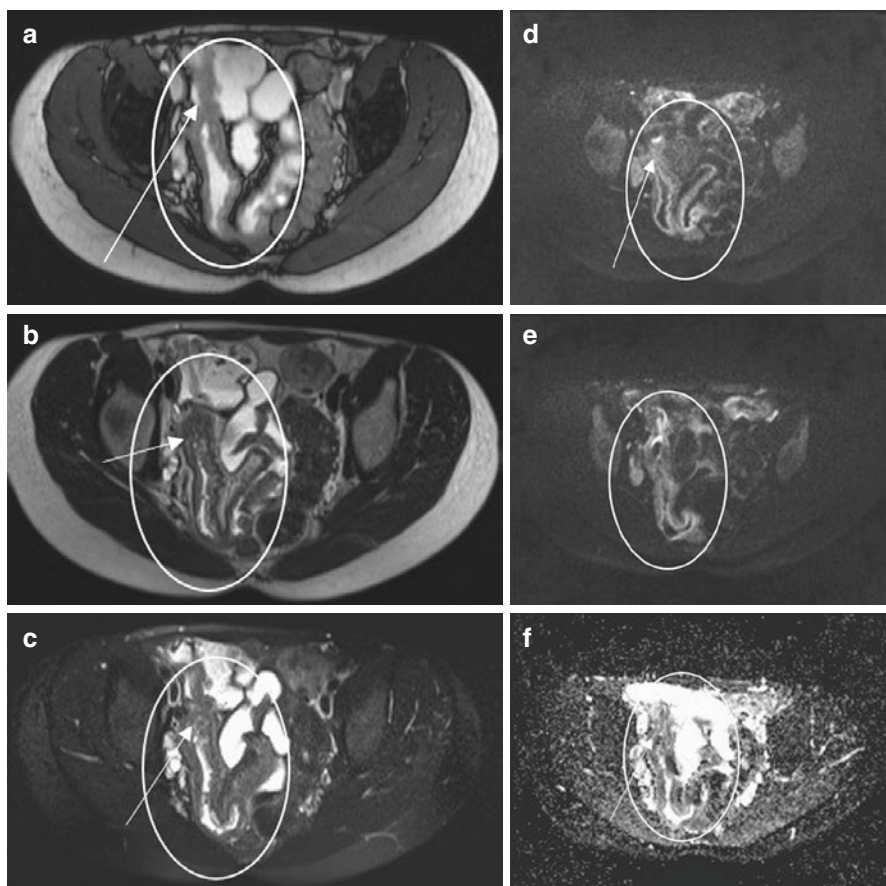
Typical appearance of a long segment (>10 cm) of very active terminal ileal (white arrow and circled area) Crohn's on conventional sequences and DWI. Mural thickening, oedema and ulceration are shown on axial Trufi (a) and HASTE sequences without (b) and with (c) fat saturation. Axial DWI images show increased mucosal signal on (d, $B = 0$; and e, $B = 600 \text{ s/mm}^2$). The ADC map (f) confirms a corresponding low signal area of restricted diffusion (white circles)
